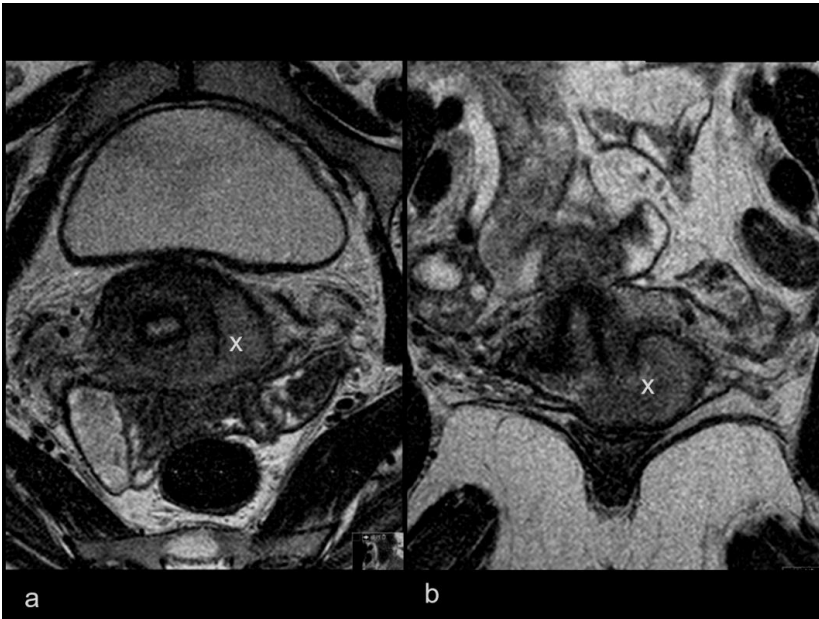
MR protocol B: T2-weighted axial oblique images perpendicular to the cervical canal (a) and coronal oblique images parallel to the cervical canal (b). A cervical tumour bulging into the left fornix is indicated with “x”.
